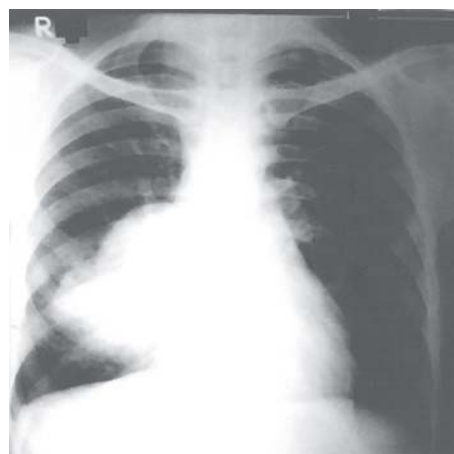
Chest radiograph (postero-anterior view) showing a well-defined mass in the right middle and lower zones.
